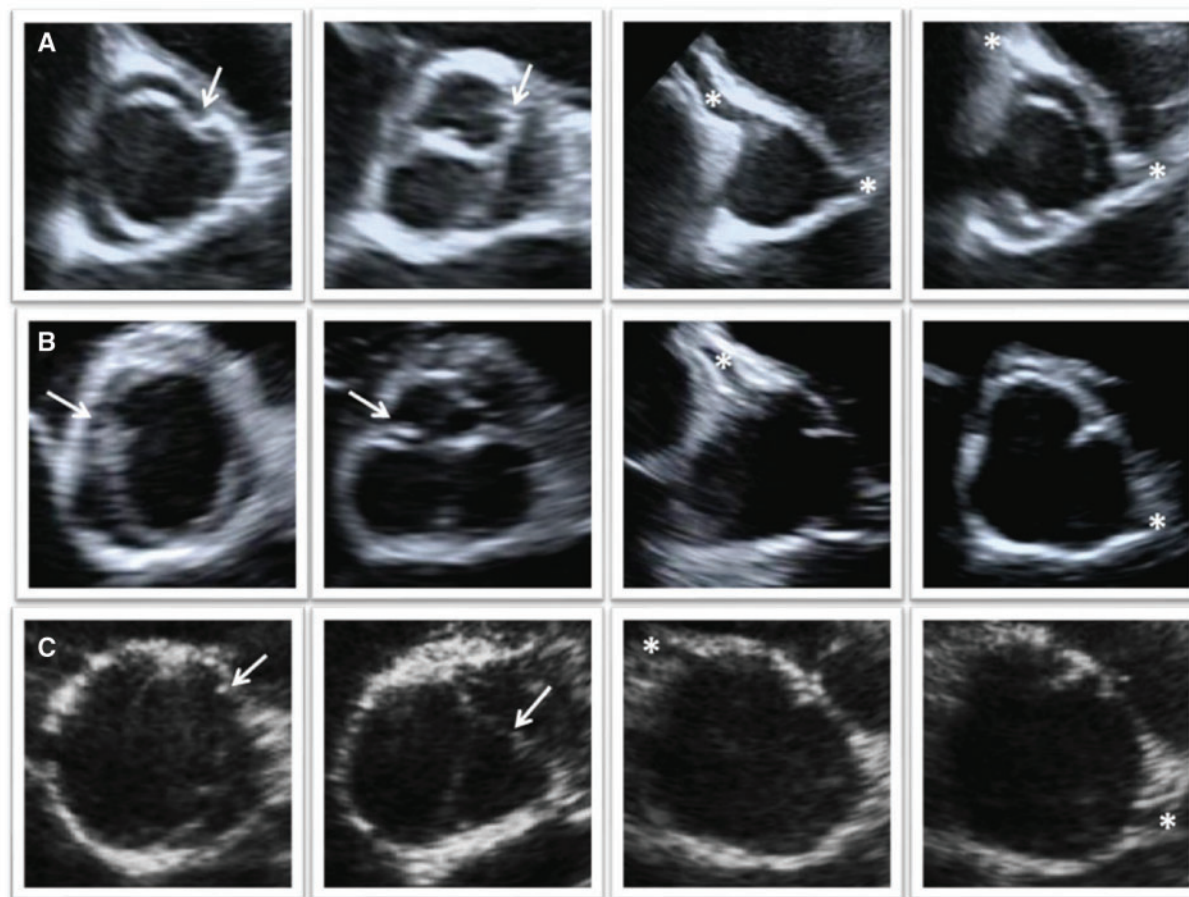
Bicuspid aortic valves morphology in echocardiographic parasternal short axis. Bicuspid aortic valve was confirmed when two cusps were clearly identified in short-axis view. (A) Type 1: right-left coronary cusp fusion (anteroposterior bicuspid aortic valve with both coronary ostium at the anterior leaflet); (B) Type 2: right-non-coronary cusp fusion (right-left bicuspid aortic valve with right coronary ostium at the right leaflet and left coronary ostium at the left leaflet); and (C) Type 3: left-non-coronary cusp fusion (left-non-coronary bicuspid aortic valve with one ostium in each leaflet). The coronary ostium was visualized in all athletes. Asterisk indicates coronary ostium and arrow indicates coronary cusp fusion.
